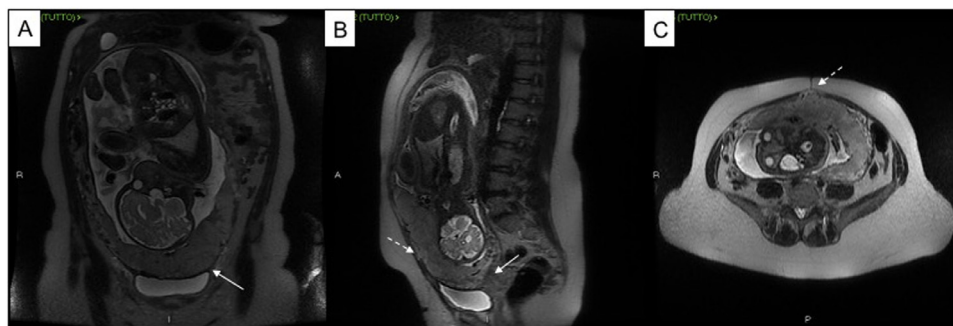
A 33-years-old female, three previous cesarean sections. Despite a scar pregnancy diagnosis, she wanted to carry on the pregnancy. MR planned at 32nd week and cesarean delivery planned at 36th week. T2-weighted MR sequences in coronal (A), sagittal (B) and axial planes (C) showing scar pregnancy with infiltration of the myometrium (placenta increta) associated with a placenta previa major.
